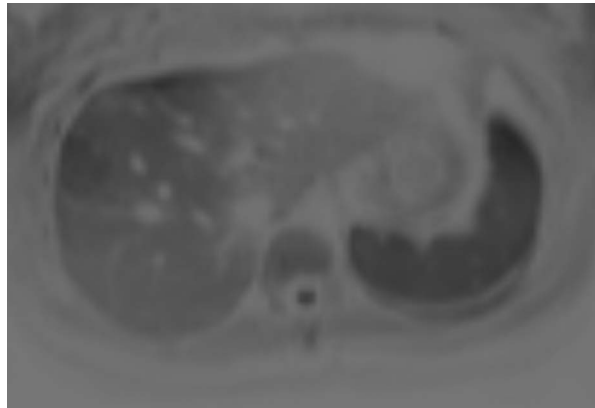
Liver. MRI. DWI (inverted grayscale). b=500. Axial plane.
